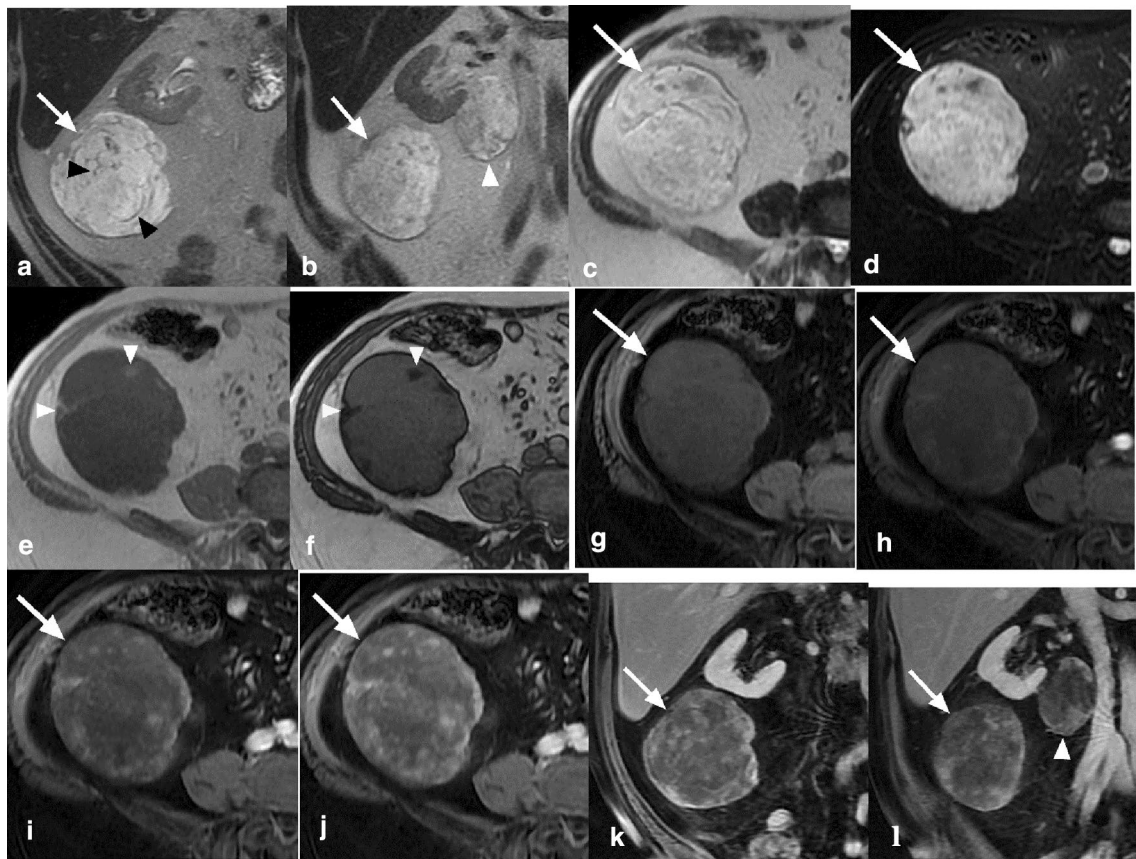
Axial MRI images at 1.5 T of two right perirenal masses in Case 1. T2-weighted coronal images a, b demonstrate two perirenal T2 hyperintense masses, the larger inferolateral (white arrows) and the smaller inferomedial (b, white arrowhead). There appear to be curvilinear hypointense septations in the masses, more prominent in the larger mass (a, black arrowheads). T2-weighted axial images of the larger mass (arrow) without (c) and with (d) fat saturation similarly show intense T2 hyperintensity. Small peripheral foci of macroscopic fat (arrowheads) within the larger mass are hyperintense
